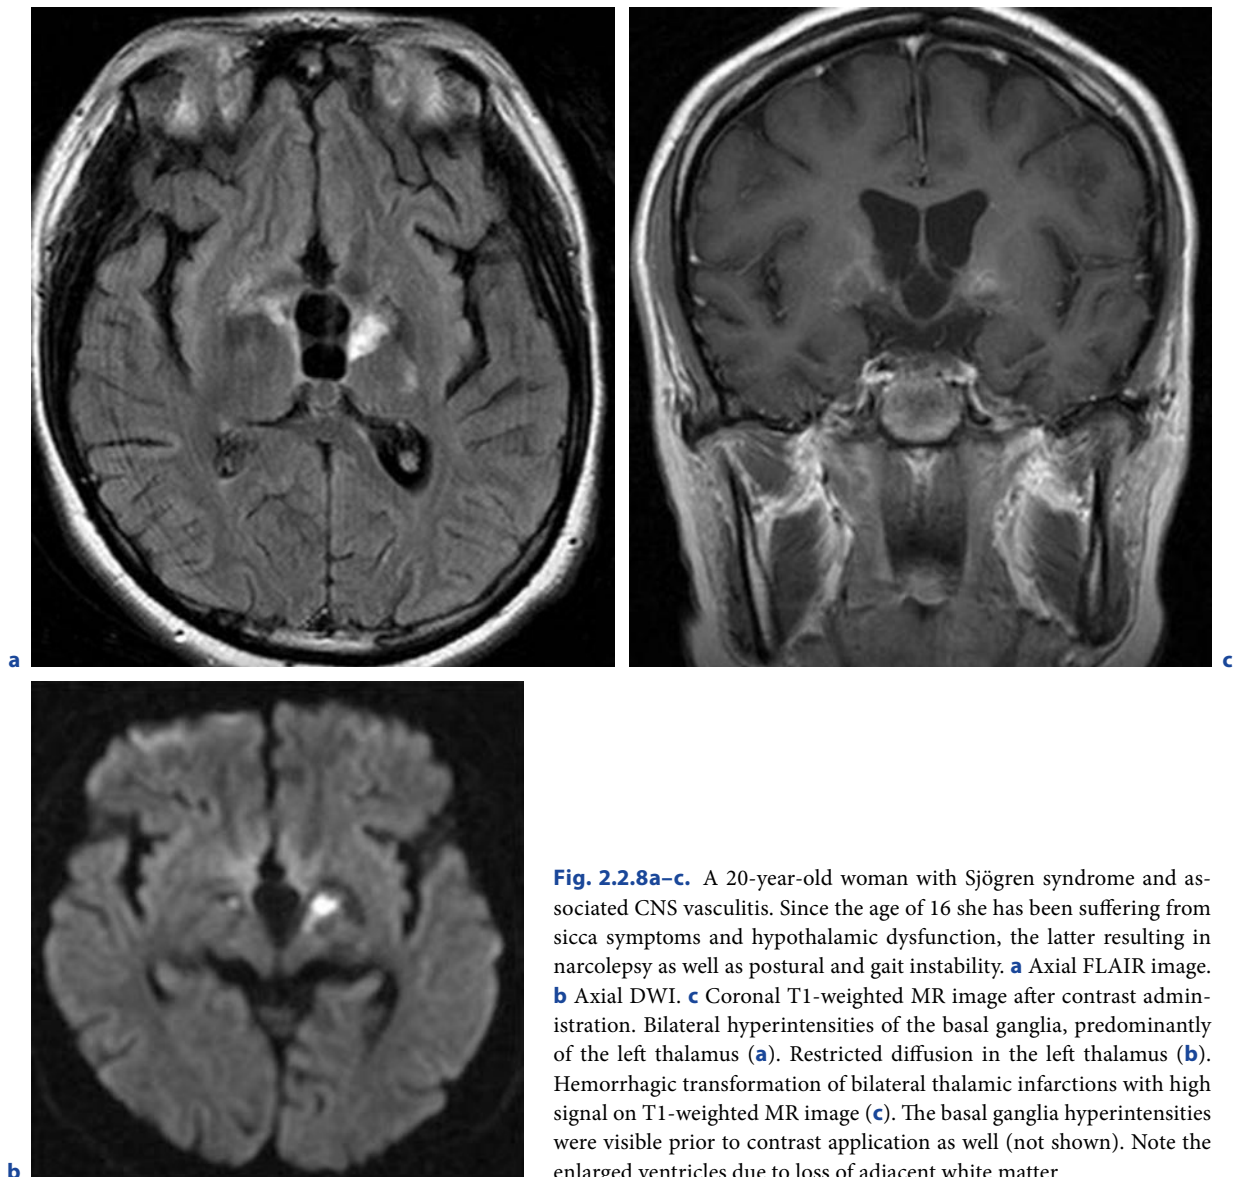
A 20-year-old woman with Sjögren syndrome and associated CNS vasculitis. Since the age of 16 she has been suffering from sicca symptoms and hypothalamic dysfunction, the latter resulting in narcolepsy as well as postural and gait instability. a Axial FLAIR image. b Axial DWI. c Coronal T1-weighted MR image after contrast administration. Bilateral hyperintensities of the basal ganglia, predominantly of the left thalamus (a). Restricted diffusion in the left thalamus (b). Hemorrhagic transformation of bilateral thalamic infarctions with high signal on T1-weighted MR image (c). The basal ganglia hyperintensities were visible prior to contrast application as well (not shown). Note the enlarged ventricles due to loss of adjacent white matter
